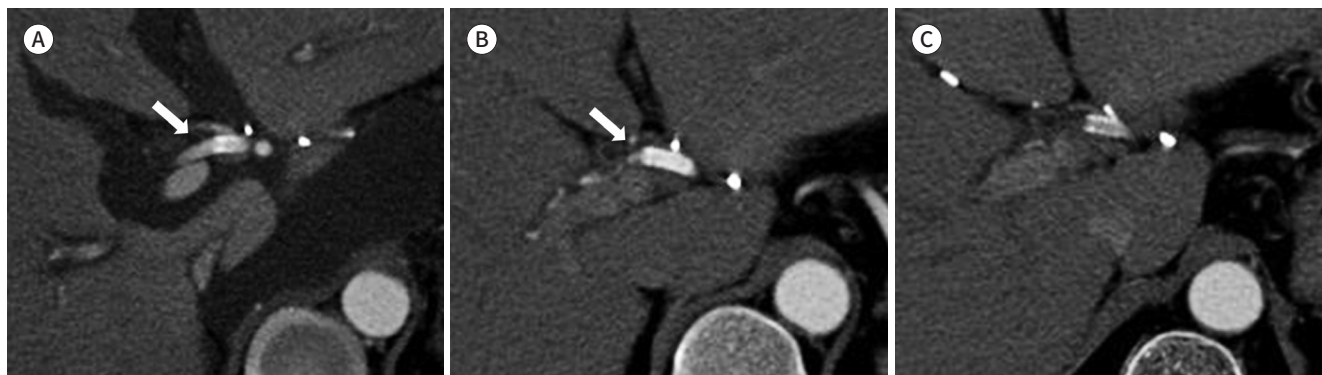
Postoperative follow-up CT scans of patient 5.
